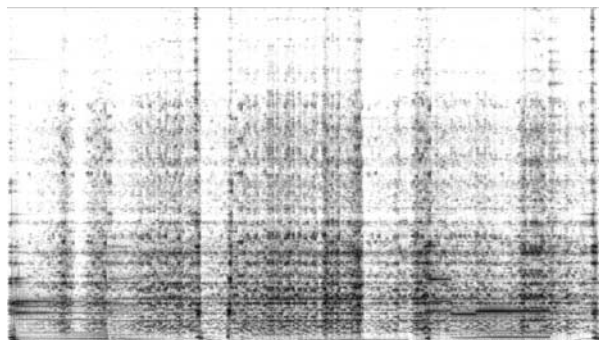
Sonogram of Francis Dhomont’s *Novars* from 2’58” to 3’35”.
